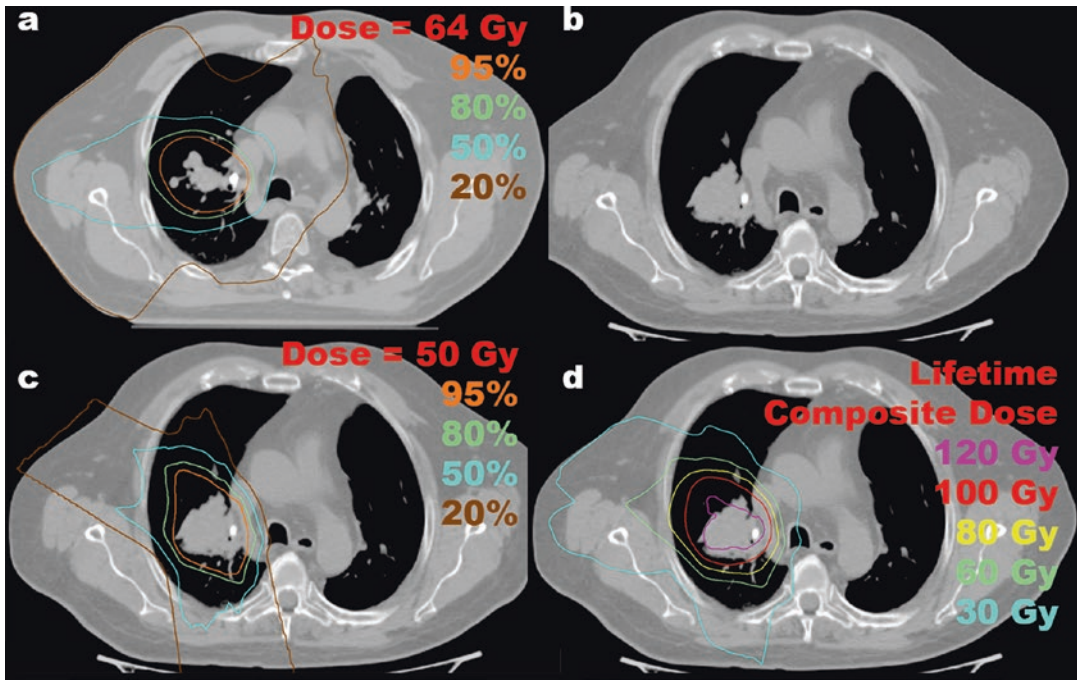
An 80-year-old man was treated for recurrent solitary lung metastasis from colon adenocarcinoma. Five years after surgery for a pathologic T3 N0 colon adenocarcinoma, he developed hemoptysis and was found to have a solitary right perihilar metastasis, biopsied as adenocarcinoma consistent with his colon primary. Given his advanced age and medical comorbidities including hypertensive cardiomyopathy, and obstructive pulmonary disease from asbestosis with poor pulmonary function tests, he was not a candidate for surgical metastasectomy. He then received thoracic radiotherapy with IMRT to 64 Gy (a) with concurrent capecitabine. Eighteen months later he developed recurrent hemoptysis, and a CT (b) showed recurrence of the previously treated right perihilar metastasis, now measuring just over 5 cm in size, without evidence of other distant disease on PET/CT. He was not felt to be a candidate for additional external beam radiation or stereotactic body radiotherapy in light of his prior radiation and tumor size. He was then referred for salvage proton therapy. He was
